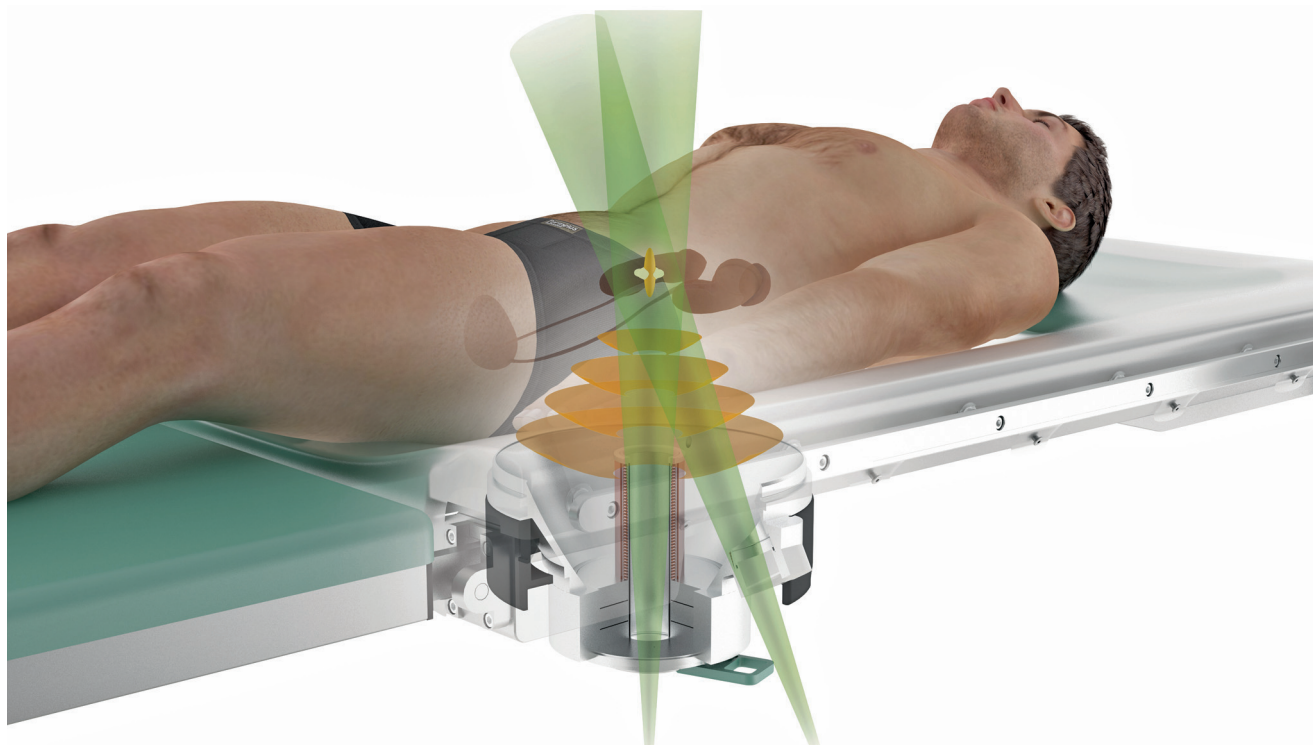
In-line localization. Fluoroscopy or ultrasound localization arranged in-line with shock wave propagation enables precise control of stone position and quality of shock wave passage
